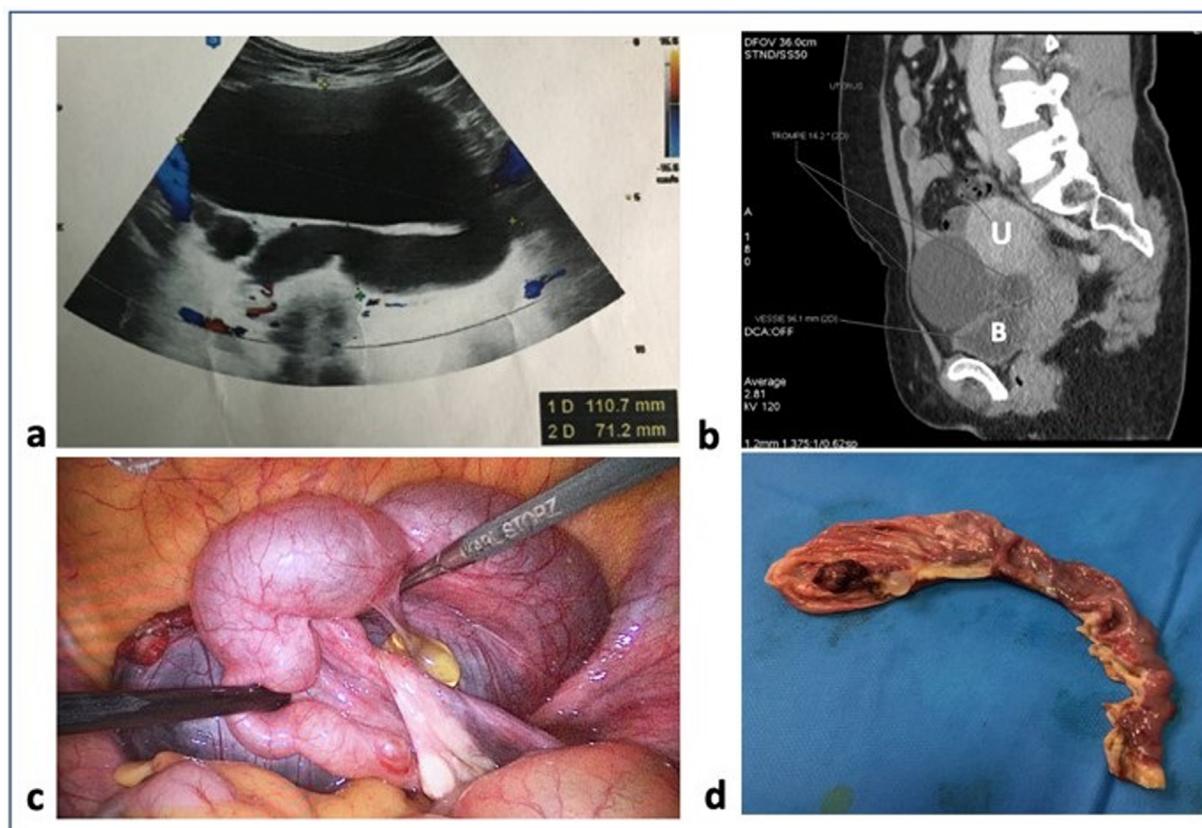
a. Initial ultrasound view showing serpiginous fluid-fluid tubular mass.
